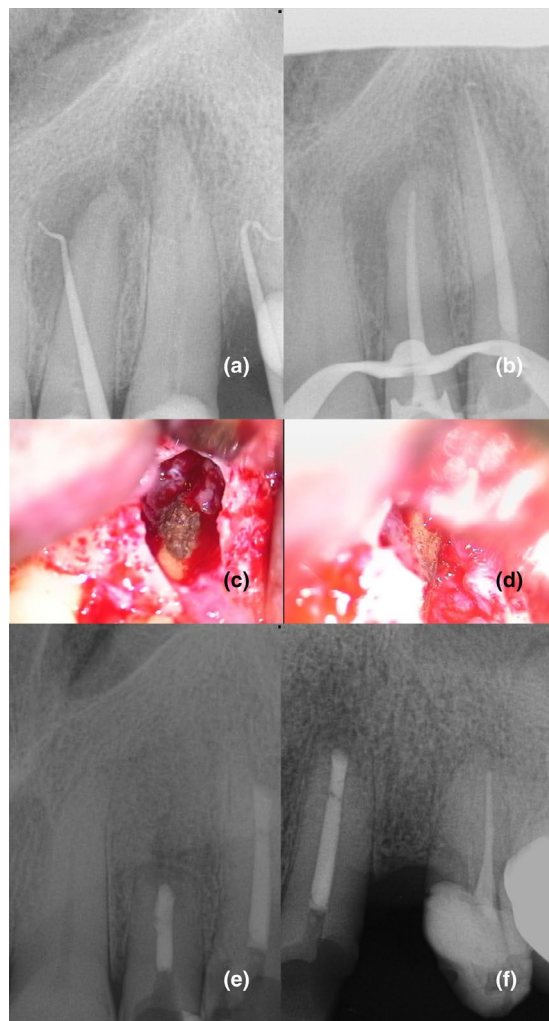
(a) Diagnostic radiographs taken at the endodontics specialist clinic, showing apical radiolucencies in teeth 22 and 23 with visible sinus tracts; (b) completed root canal treatment; (c, d) clinical photographs of tooth 22 (c) and tooth 23 (d) during apical surgery, revealing calculus-like structures; and (e, f) radiographs taken at the 11-month postoperative follow-up, demonstrating healing in teeth 22 and 23. All radiographs were captured using SIRONA imaging equipment.
